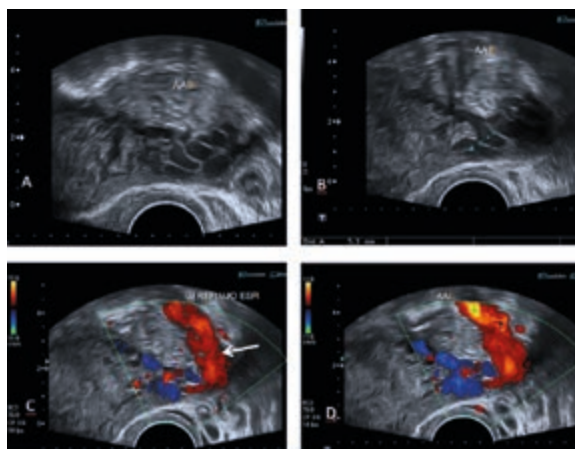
A) and B). TV ultrasound of the left adnexal area (LAA) showing multiple dilated venous structures of the periuterine plexus. C) and D) CDE assessment showing spontaneous reflux from an incompetent left gonadal vein (white arrow) that increases after the Valsalva maneuver, confirmed through the intense color red seen and greater refill of the venous structures.
